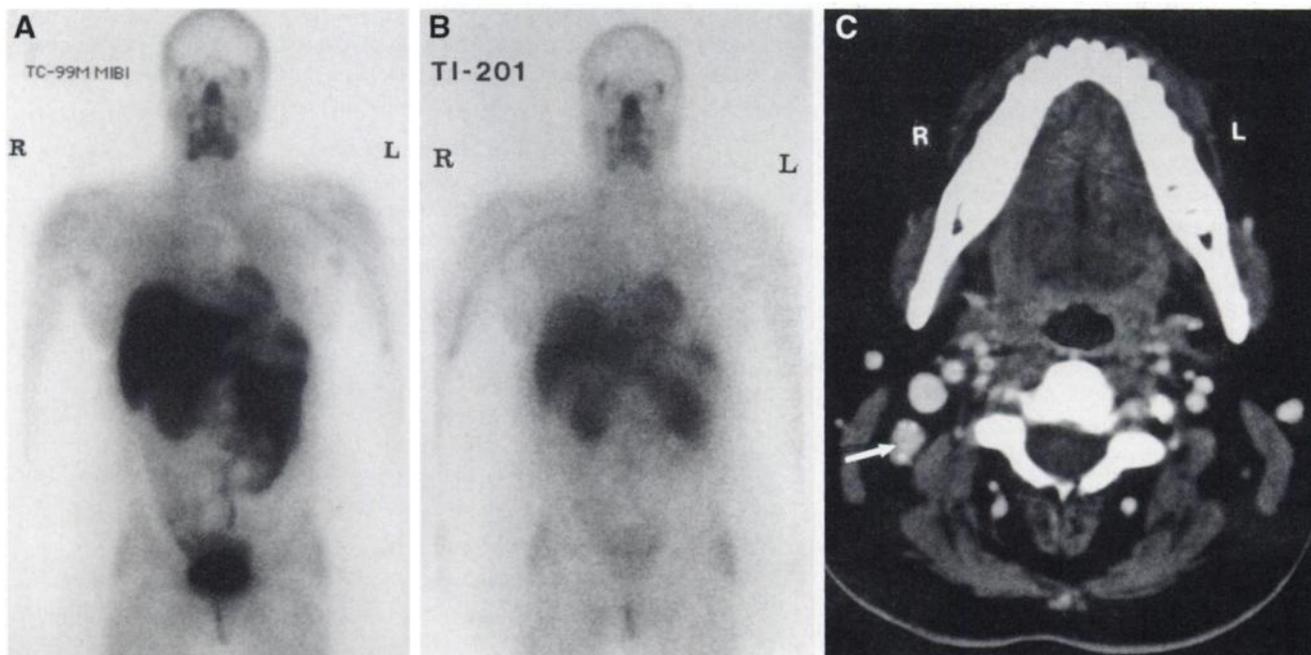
This 42-y-old man had three negative ^{131}I scans (1, 2 and 4 y after 5476 MBq [148 mCi] postoperative ^{131}I therapy) for multifocal papillary thyroid cancer and 24 positive lymph nodes. False-negative methoxyisobutyl isonitrile (MIBI) (A) and ^{201}Tl total-body (B) scans (slight asymmetric uptake in region of salivary glands). (C) CT scan shows 1- to 2-cm calcified right cervical lymph node (arrow) containing metastatic cancer.
